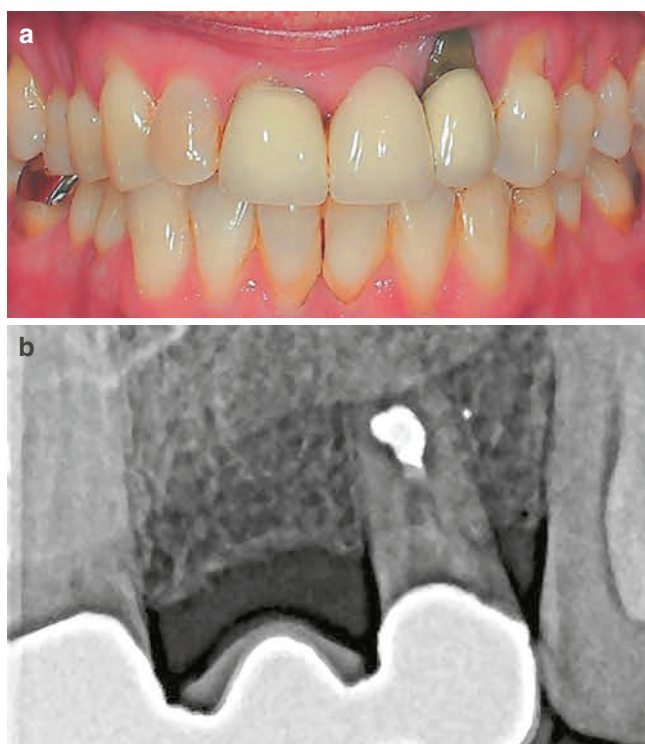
What happened? The area of #10--12 has thin gingival phenotype which is reflected by generalized recession in this area due to toothbrush abrasion (a). After the prosthesis was placed, #10 displayed continual increase in gingival recession. Radiographs reviewed that #10 was treated with retrograde procedure but the canal has not been obturated (b). The endodontic lesion resulted in venting of the infection resulting in additional attachment loss and gingival recession
